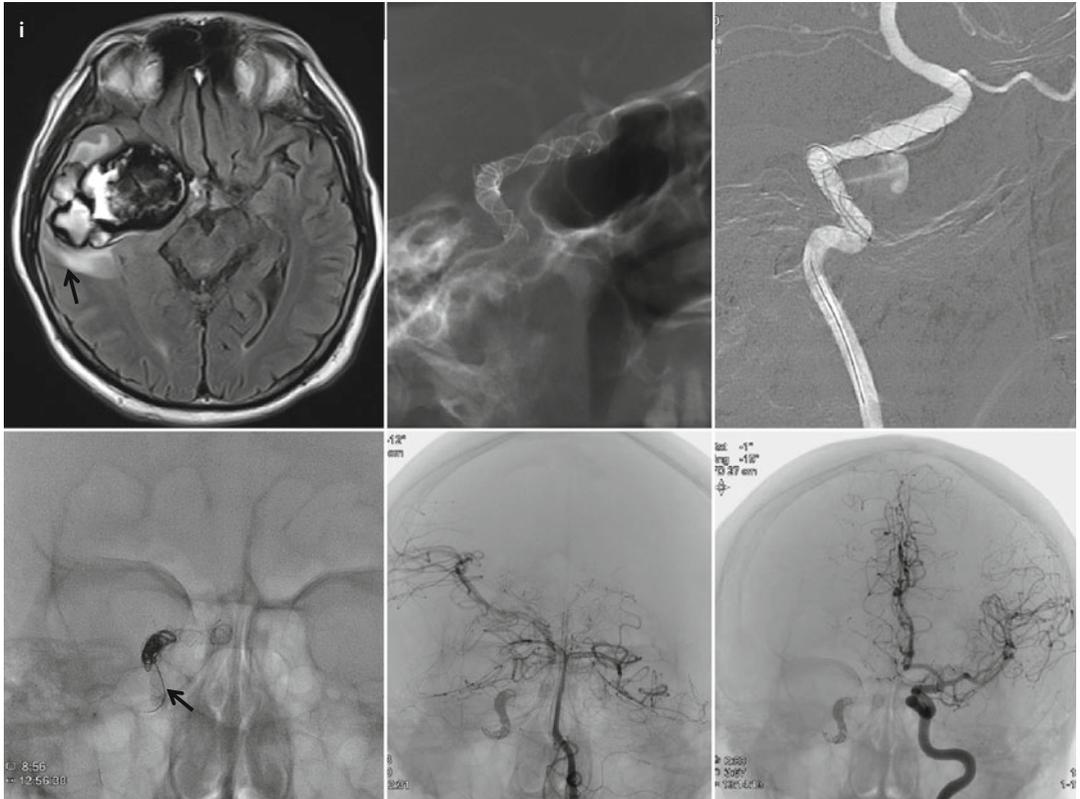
(continued) (i) Twelve months after the third treatment, the patient presented with severe headaches. MRI reveals increased size of the thrombosed aneurysm with recurrent vasogenic edema (*arrow*) in the temporal lobe. VASO CT® and corresponding DSA shows persistent inflow jet phenomenon into the antero-medial portion of the thrombosed aneurysm. The patient was treated by parent vessel occlusion of the ICA cavernous segment. This was accomplished using a dual-lumen balloon catheter (Scepter C®) (*arrow*) and subsequent coiling through its lumen. Postprocedural vertebral and internal carotid angiograms reveal adequate opacification and perfusion of the right cerebral hemisphere across the anterior and posterior communicating arteries. The patient had gradual relief of his headaches with complete relief after 1 week
